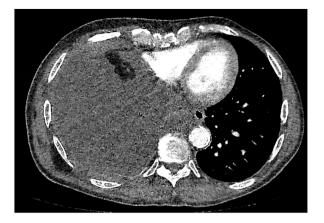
Computed tomography of the chest (axial view) showing mediastinal shift with right atrial compression.
